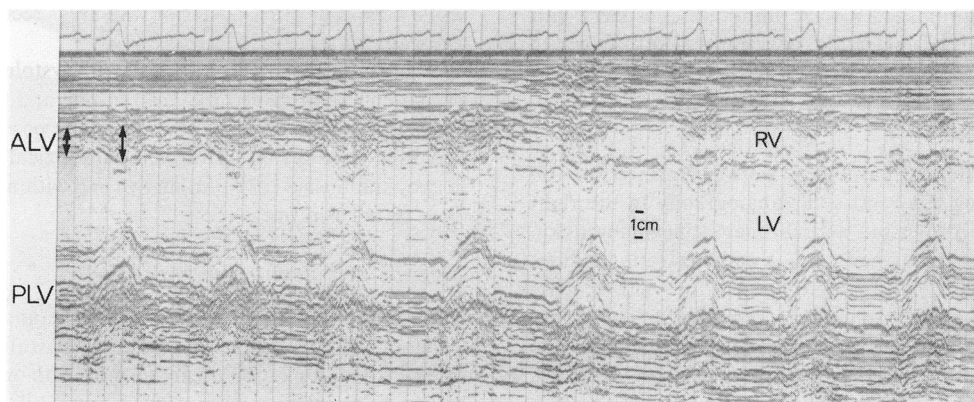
Normal anterior left ventricular wall (ALV) echogram and linear scan. Echoes from the ALV are shown on the left. With linear movement of the transducer to the parasternal region (on the right), echoes from the right ventricular wall, interventricular septum and posterior LV wall are recorded. RV = right ventricle, LV = left ventricle, PLV = posterior left ventricular wall.
